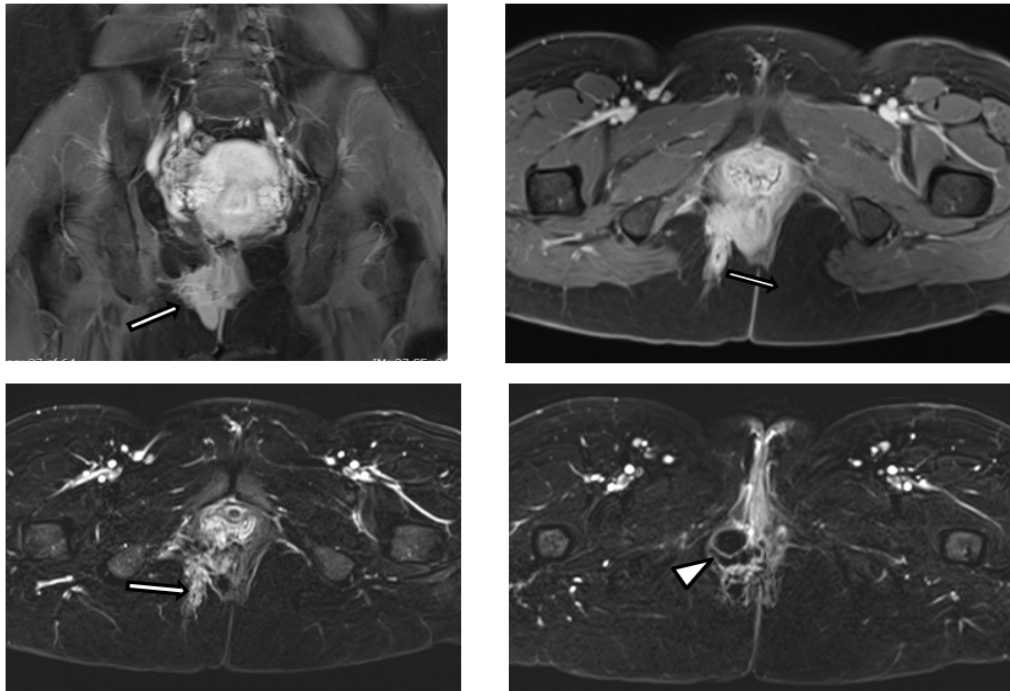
MRI Pelvis: Post IV Contrast, Sagittal (A), Axial without subtraction (B) and with subtraction (C,D): Show enhancement of the fibrotic changes (arrows) and cysts wall (arrow head).
